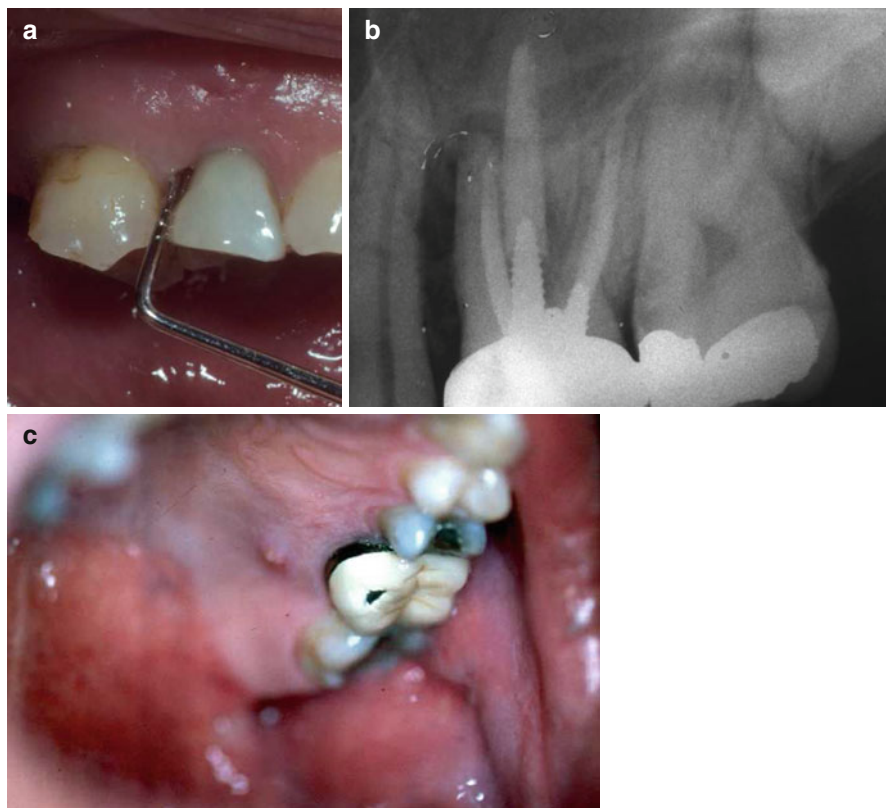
Deep probing defects may occur on different surfaces but mostly in the buccal aspect as the buccal cortical plate is much thinner than the lingual and the palatal ones. (a) Mesiobuccal probing defect in a maxillary lateral incisor. (b) Periapical radiograph of a maxillary molar, showing the large bone loss along the MB root causing deep probing defects in the buccal as well as in the palatal. (c) A sinus tract can be seen as well on the attached gingivae at the palatal aspect
